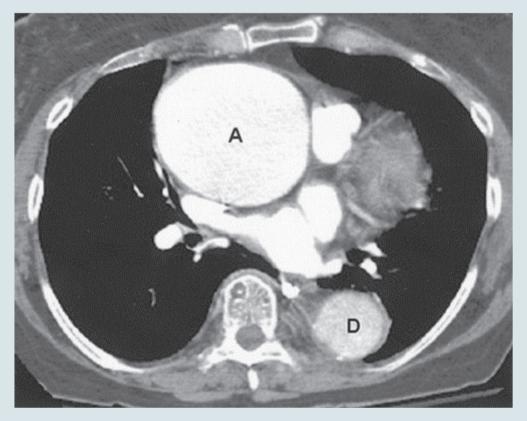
Contrast-enhanced CT scan demonstrating a 7.5  $\times$  8.3 cm ascending thoracic aortic aneurysm. A – indicates ascending; D – descending
